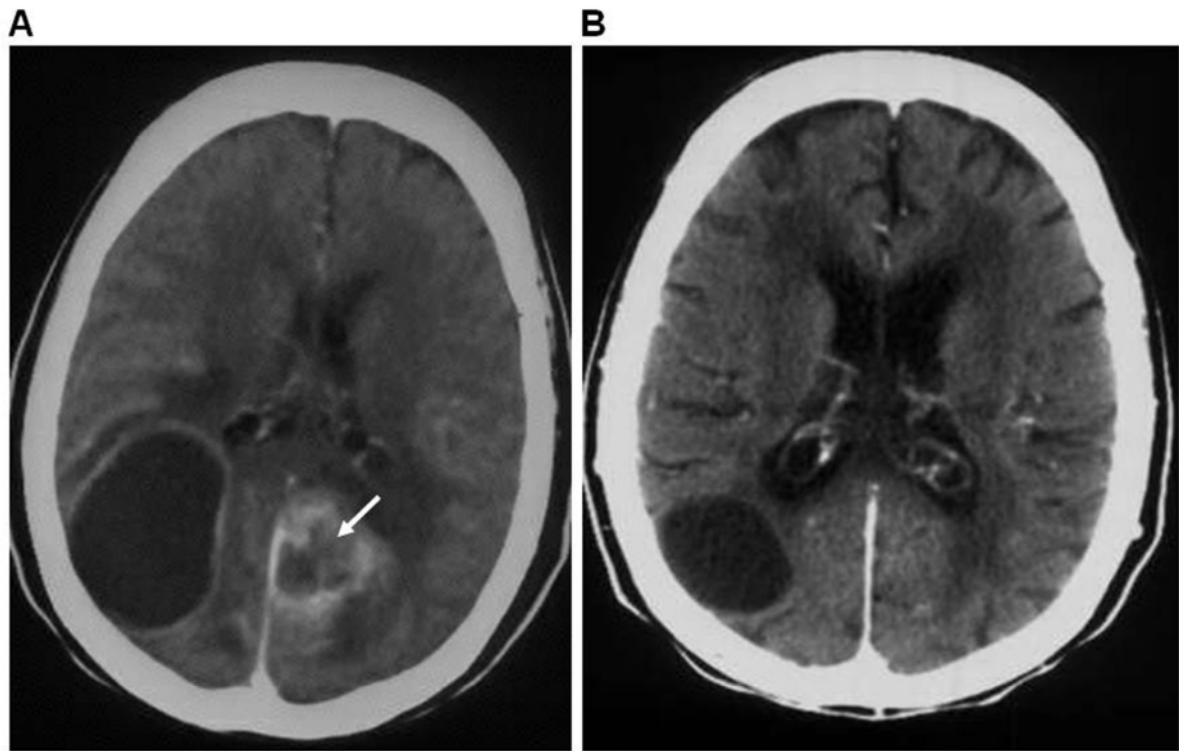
Brain CT scan of patient # 9 - a female with lung adenocarcinoma and a brain metastasis as the only metastatic location -harbouring exon 19 deletion-. A. An isolated brain metastasis in the left hemisphere before initiating erlotinib. The white arrow shows the brain lesion. Encephalomalacia is seen in the right hemisphere. B. Complete response of the brain metastases after two months of treatment with erlotinib.
